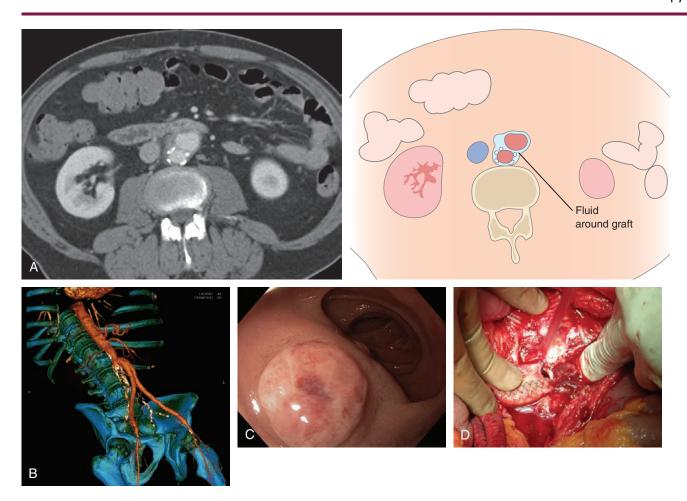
AORTOENTERIC FISTULA A, Computed tomography (CT) shows fluid around the graft (*right*). B, CT with vascular image reconstruction shows the abnormality of the right iliac artery. C, Round, raised polypoid lesion in the duodenum. D, As seen at the time of surgery, the fistulous opening is obvious.
